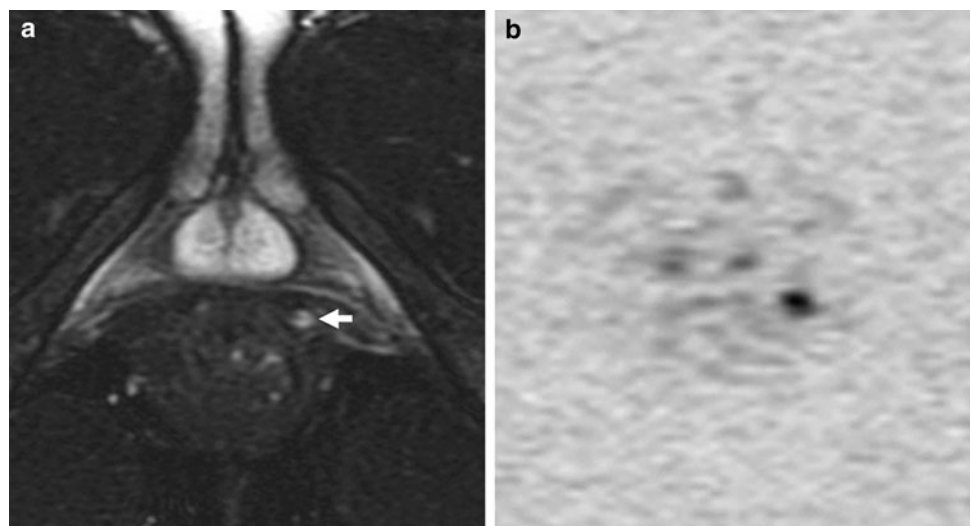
A 34-year-old man presented with an anal fistula and gluteus abscess due to Crohn's disease. a The small anal fistula and gluteus abscess (*arrow*) show a high signal on fat-suppressed T2WI. b The fistula and gluteus abscess both have a high signal intensity on DWI. The gluteus abscess is large, while the anal fistula is a relatively small focus. Despite this, it is easy to find due to its high signal intensity on DWI
